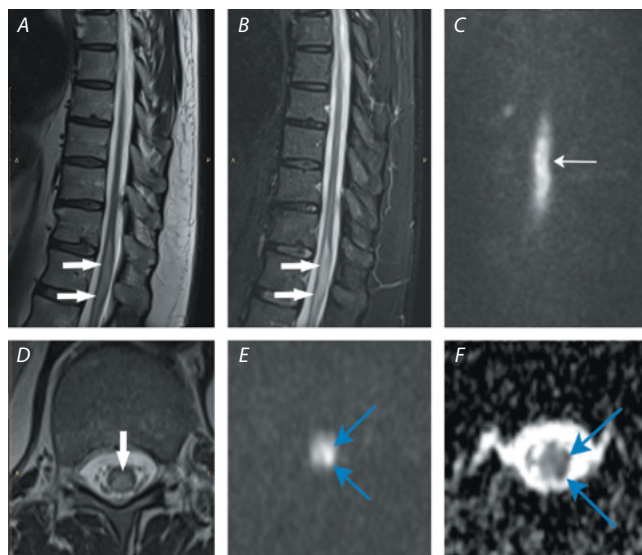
MR image of patient P. with SC infarction at Th11–Th12.
